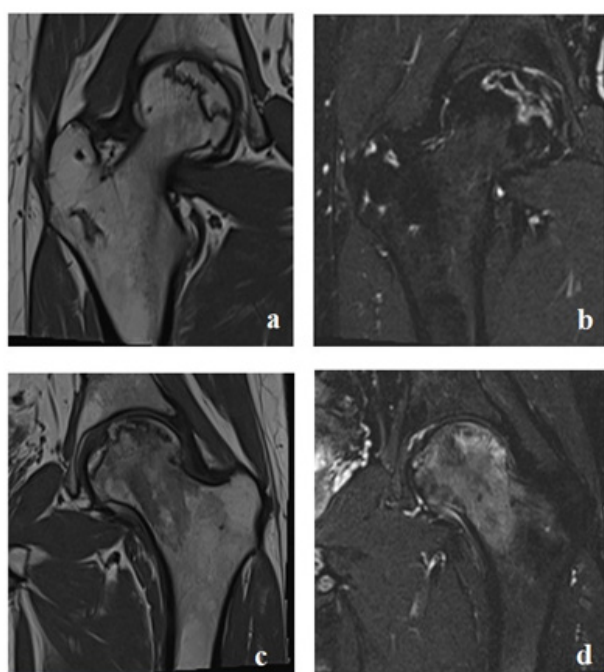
MRI images obtained in the coronal plane showing Stage-2 osteonecrosis in both hip joints.
